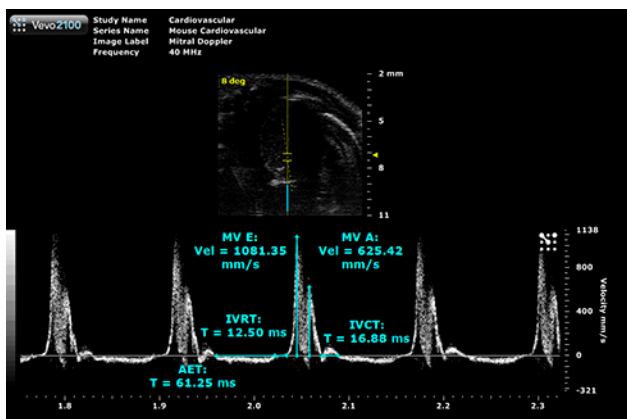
Pulsed Wave Doppler is used to assess flow through the mitral valve. Here the peak velocities of the early (E) and atrial (A) peaks are measured, along with the isovolumic relaxation and contraction times (IVRT and IVCT) and the aortic ejection time (AET). The latter three measurements are used in the myocardial performance index.
